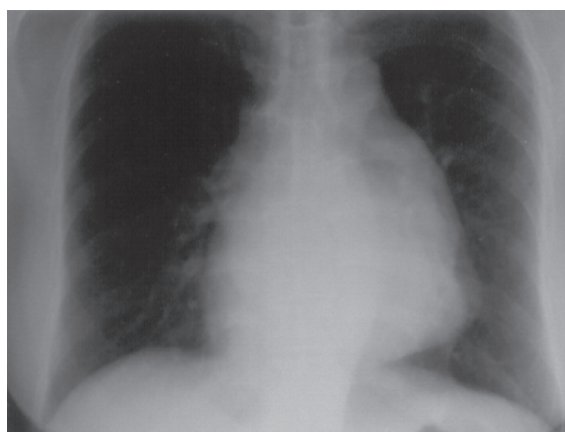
Chest radiograph showing an unusual double profile of the left heart border.
